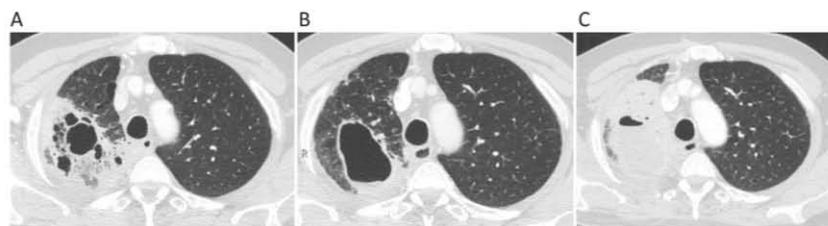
A–C. Patient 14. A) Chest CT scan shows a mass with multiple cavities at the cancer diagnosis. (August 2010). B) Progressive cavity infiltrate at *Aspergillus* spp. detection (September 2010). C) Progressive consolidation with abscess formation after *Aspergillus* spp. detection (October 2010).
